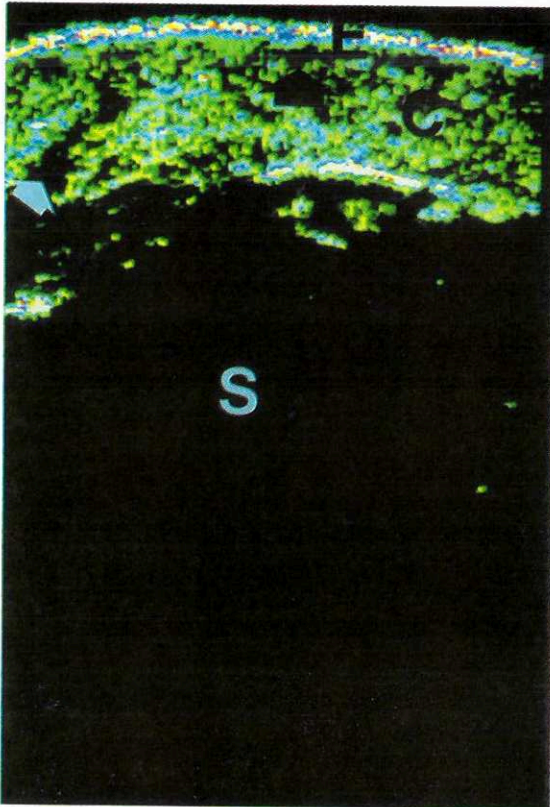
Ultrasound B-scan of healthy skin on the right lower leg (Case Study 3) (E: entry echo; C: corium; S: subcutaneous fatty tissue; black arrow: loosely structured subepithelial region; white arrow: hair follicle).
